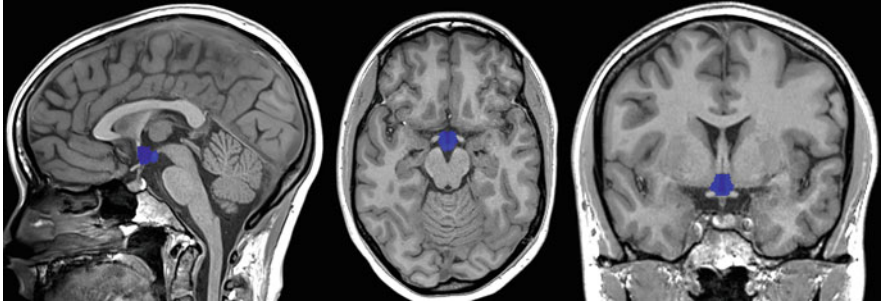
Manual segmentation (blue) of the hypothalamus in orthogonal views of a T1-weighted image (left: sagittal, middle: axial, right: coronal)
